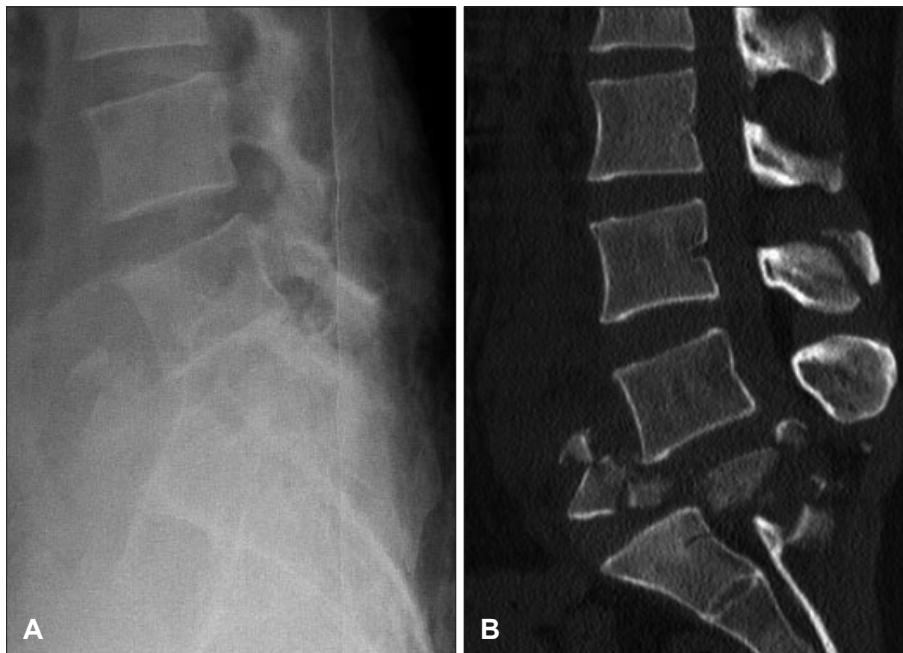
A: Fracture of the fifth lumbar vertebra-lateral view. B: Fracture of the fifth lumbar vertebra-CT sagittal reconstruction.
